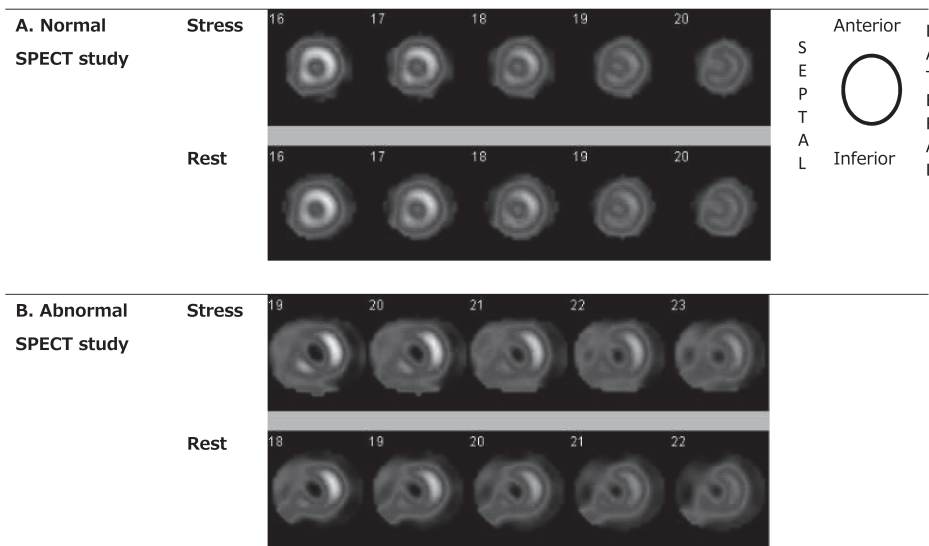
Example of ^{99m}Tc-sestamibi stress-rest SPECT myocardial perfusion imaging. A. Normal SPECT study. B. Abnormal SPECT study: perfusion defects anterior and septal.
